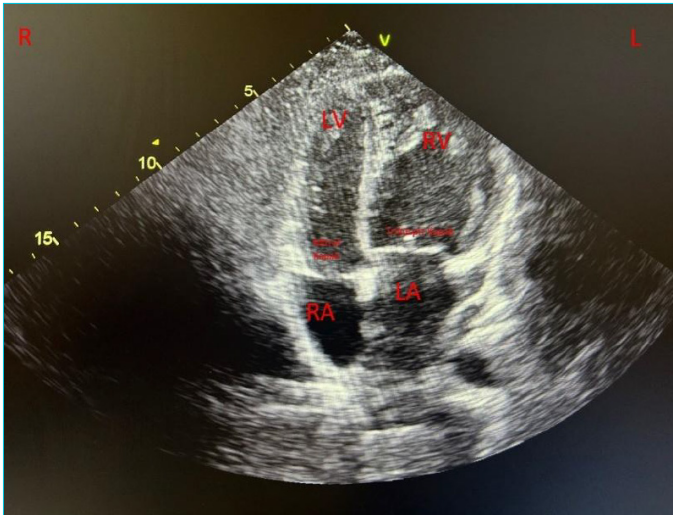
Echocardiography (ECHO) image of our patient; pulmonary veins-left atrium-tricuspid valve-right atrium-aorta-systemic circulation is observed on the left. On the right, systemic venous flow-right atrium-mitral valve-left ventricle-pulmonary artery-lungs are observed.
